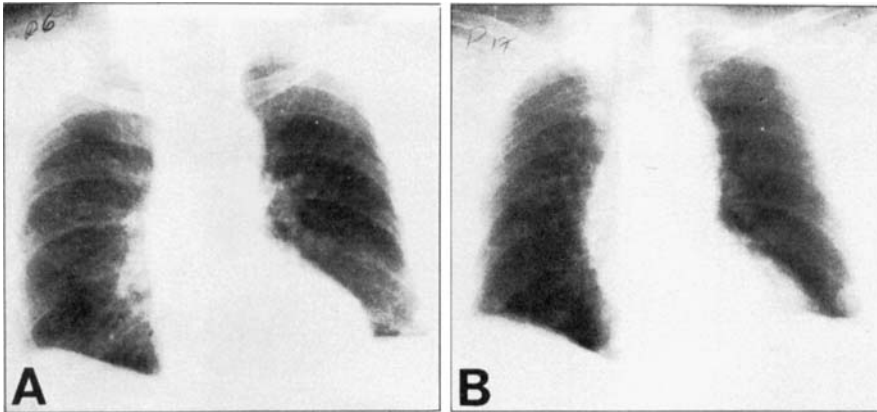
Roentgenologic survey of lungs before (A), and 2 years after (B), introduction of ^{35}S -sulfate treatment. Widespread metastases were observed on both occasions, but there is no evidence of progress in the disease.
